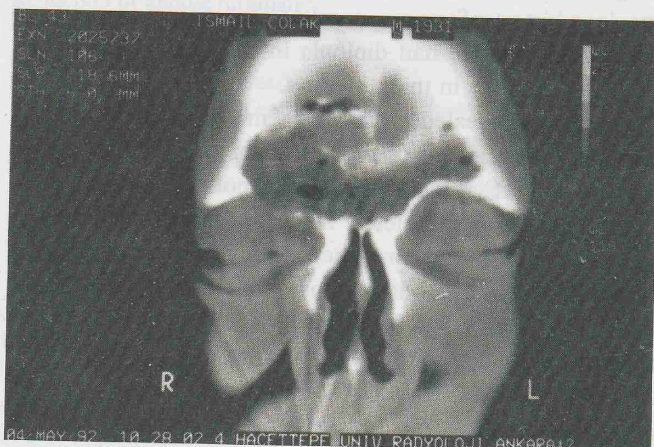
Post-operative CT scan shows no residue and obliterating materials.
